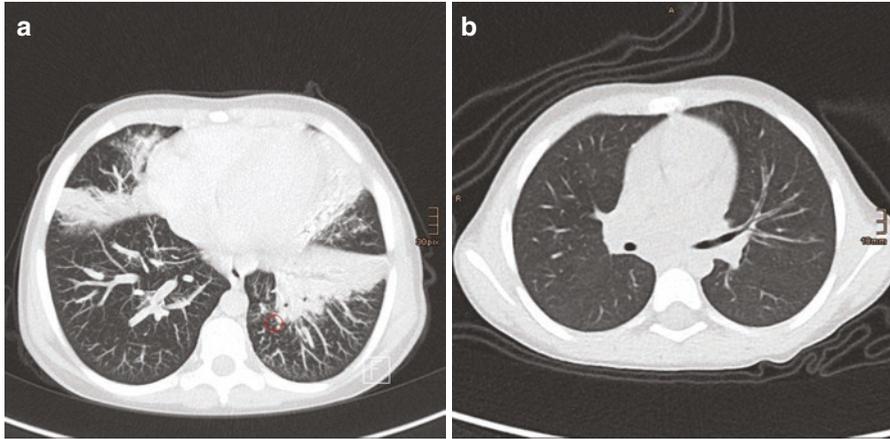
(a) Chest CT of a 9-year-old boy with APDS1. Areal hyperintensities in the right middle lobe and the left lower lobe with positive bronchoaerogram and signs of bronchiectasis. Several small speckled consolidations (see red circle). (b) Chest CT of a 6-year-old girl with APDS2 and bronchiectasis
